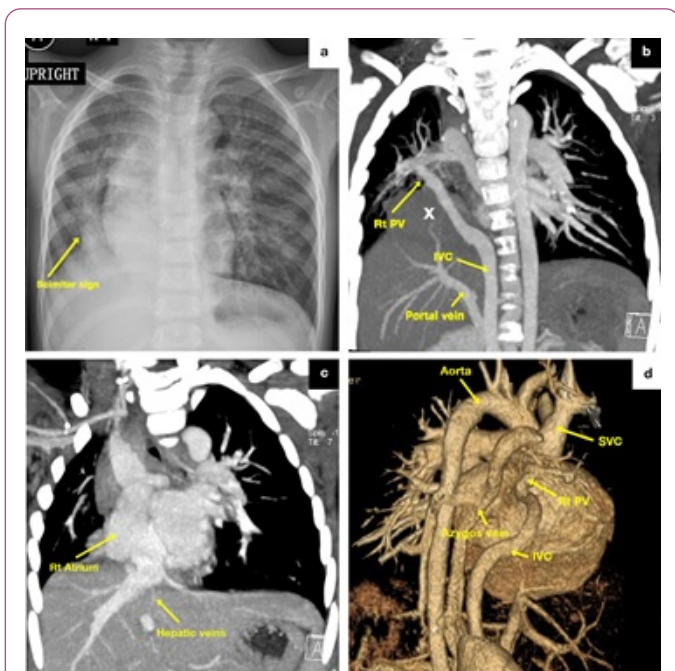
a Chest radiograph with Scimitar or "Turkish sword" sign, b-d. CT thorax images showing diaphragmatic hernia (marked as X in b) and the anomalous vascular connections (Rt PV= right pulmonary veins, IVC = inferior vena cava, SVC = superior vena cava).
